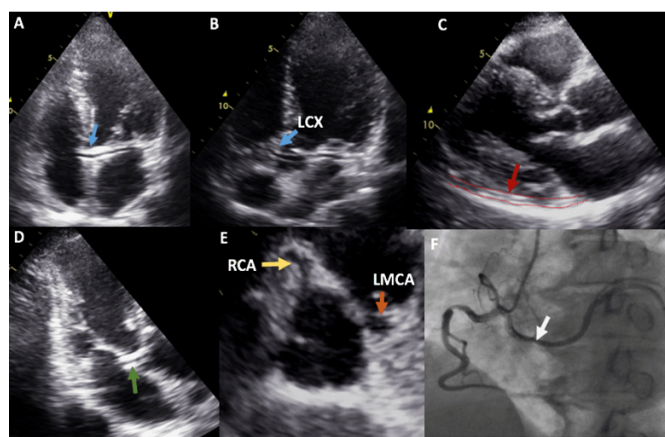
(A) Anomalous coronary artery on echocardiography. In apical four-chamber view, a coronary artery is found arising from right side of aortic root, (blue arrow), (B) Anomalous coronary artery on echocardiography. In apical five-chamber view, a coronary artery is found arising from right side of aortic root, entering into left atrioventricular groove (blue arrow), (C) Course of anomalous coronary artery. The part of the anomalous course of coronary artery was also depicted on parasternal long axis (PLAX) view (red dotted lines), (D) Course of anomalous coronary artery. The part of the anomalous course of coronary artery was also depicted on apical two-chamber view (green arrow), (E) Origin of coronary arteries. Left main coronary artery (LMCA) is arising from left coronary sinus as shown on parasternal short axis view (orange arrow), RCA is arising from right coronary sinus as shown on parasternal short axis view (yellow arrow), and (F) Anomalous artery on coronary angiogram. Anomalous origin of left circumflex coronary artery is depicted on conventional coronary angiogram (white arrow).
